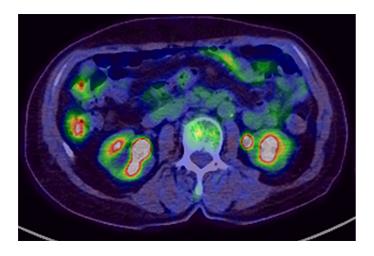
Follow-up 18Fluorodeoxyglucose positron emission tomography/computed tomography at 60 mo after complete remission. <sup>8</sup>Fluorodeoxyglucose positron emission tomography/computed tomography showed no abnormal fluorodeoxyglucose accumulation.
